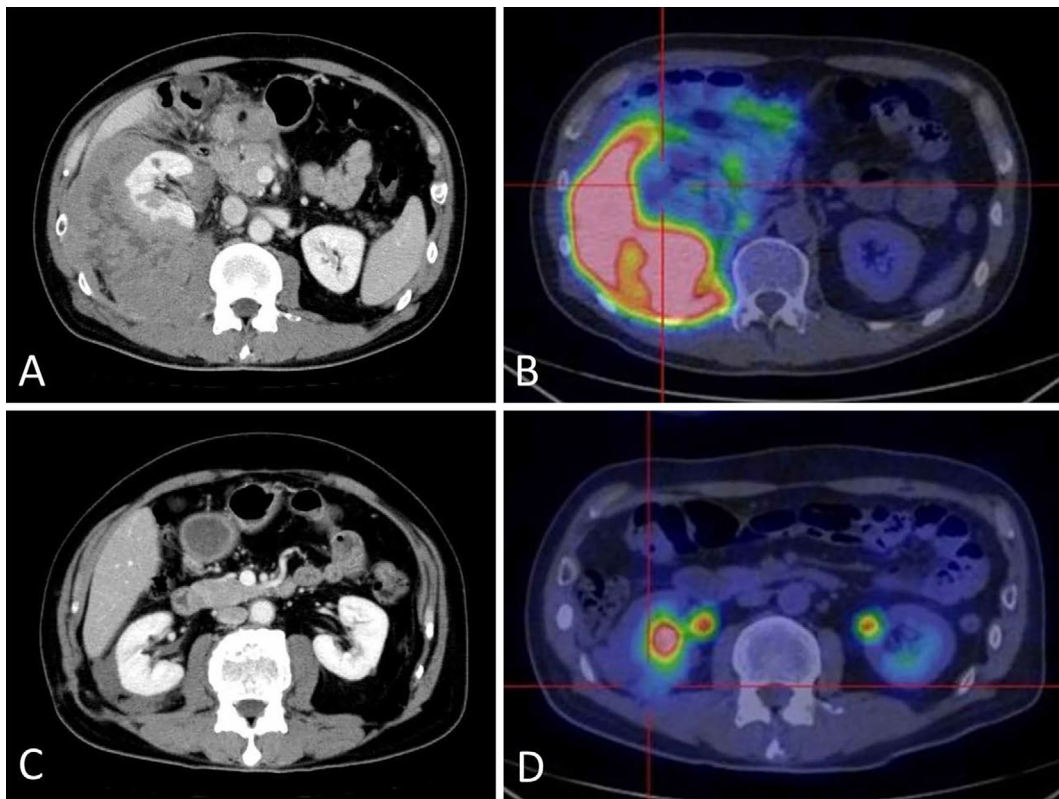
A contrast enhanced CT and PET-CT before treatment shows bulky retroperitoneal mass with high uptake of fluorodeoxy glucose (FDG) (A, B). A contrast enhanced CT and PET-CT after treatment shows shrinkage of the tumor with weak uptake of FDG (C, D).
